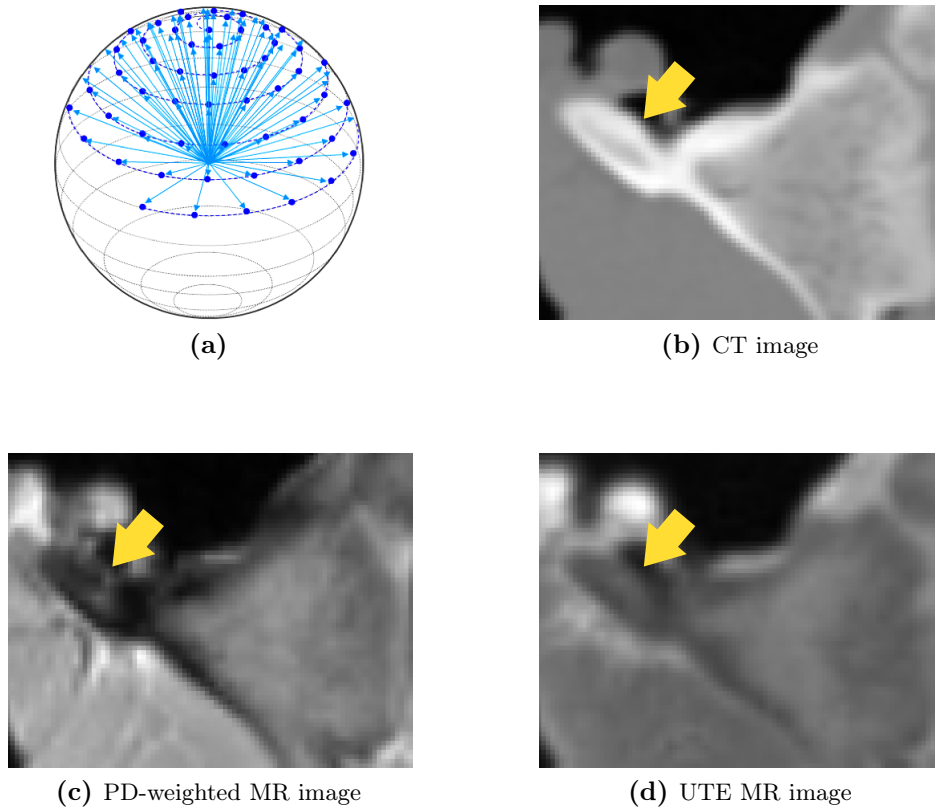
(a) 3D radial k -space sampling of applied UTE sequence, adopted from [Jellus \(2010\)](#); (b - d) examples of MR and CT images of bones.
